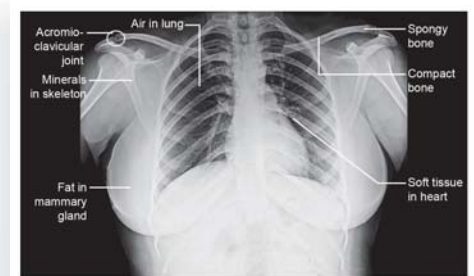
X-ray chest [posteroanterior (PA) view]. Source: Saptagiri Scan Center, Tirupati.
